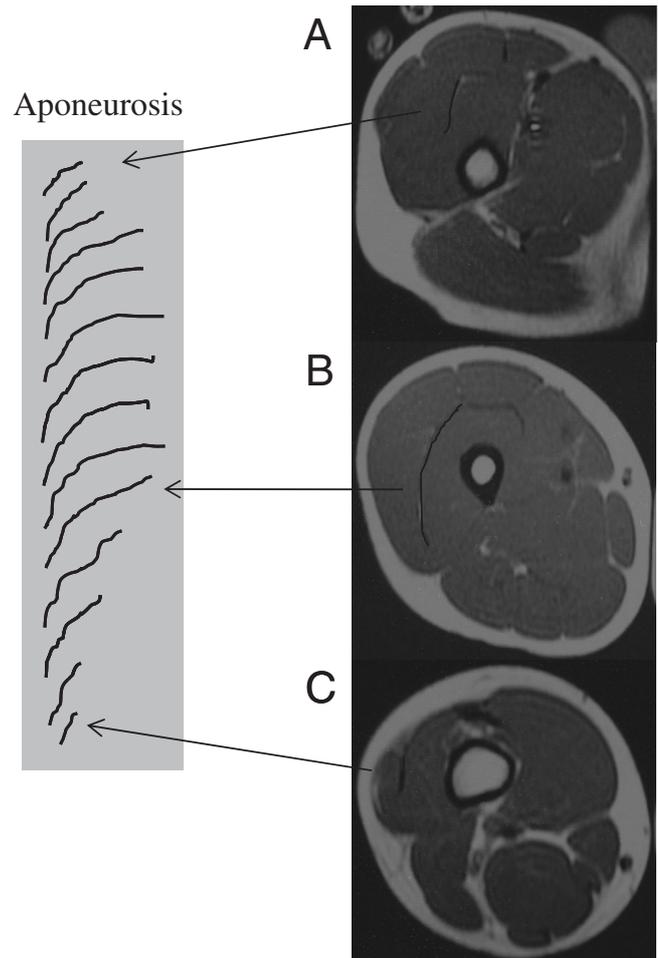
Typical magnetic resonance images of the thigh, including the most proximal slice in which the aponeurosis was visible (A), a middle part (B), and the most distal slice in which the aponeurosis was visible (C). The visible black segment between the vastus lateralis (VL) and vastus intermedius muscles in the MRI image was defined as the deep aponeurosis of the VL muscle. The length of the visible black segment was measured as aponeurosis length.
